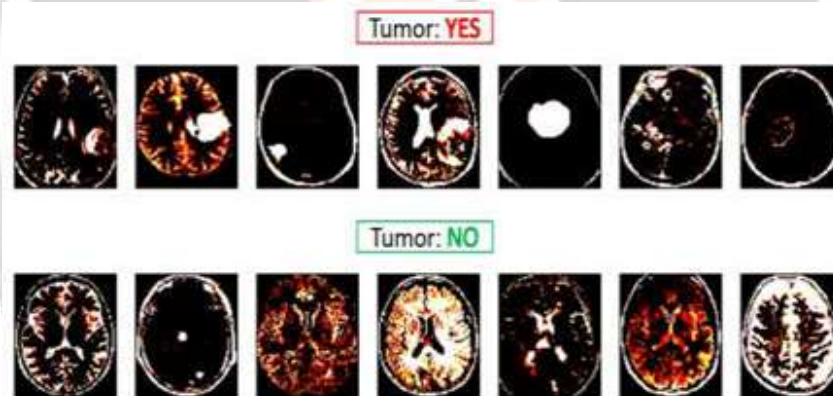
Resized MRI images of the brain
